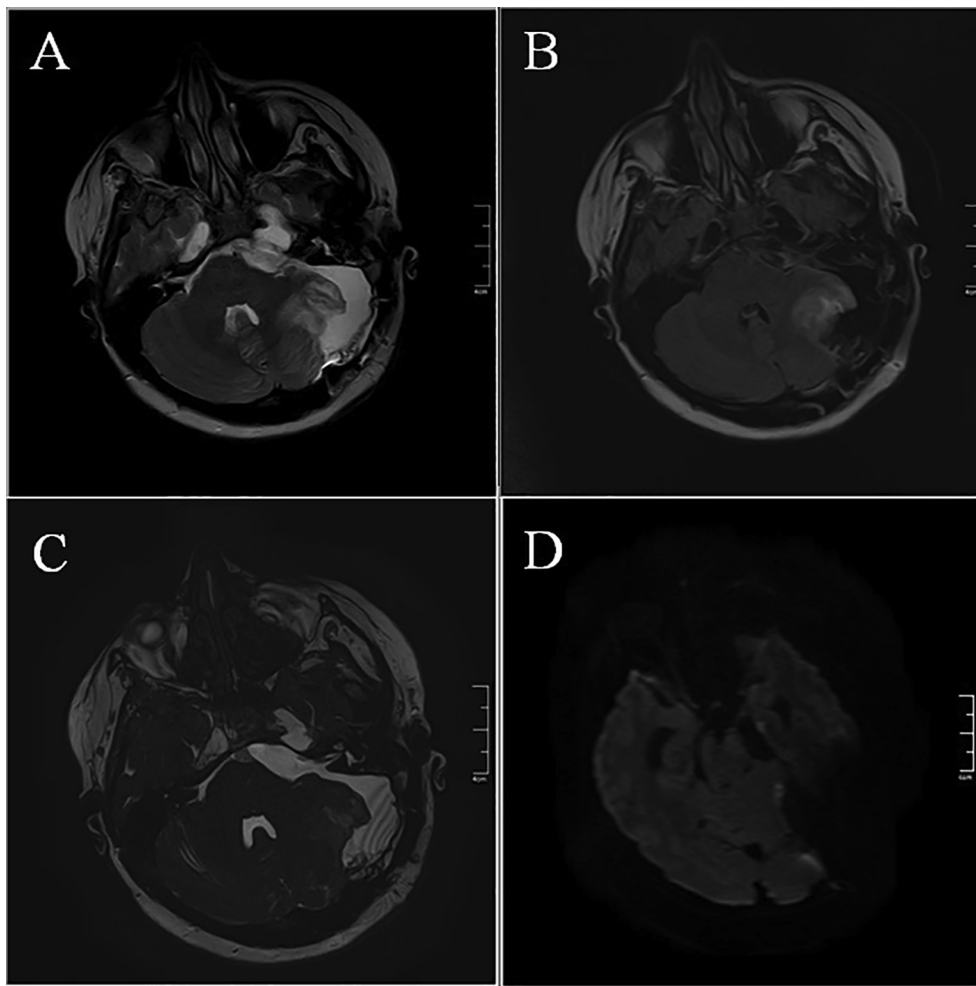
Post-operative magnetic resonance images (MRIs). A. T2-weighted MRI. B. Fluid-attenuated inversion recovery image. C. = Three-dimensional steady-state free precession image of the internal auditory canal. D. Diffusion-weighted image.
